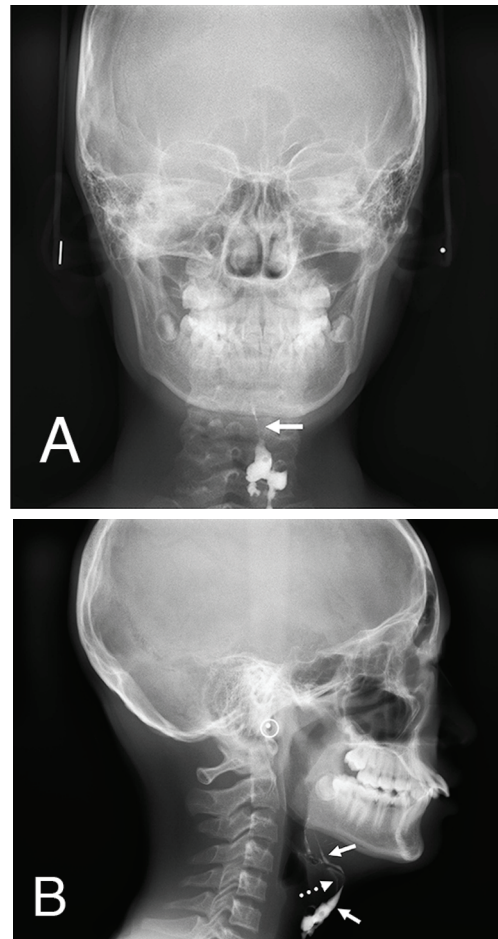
Fistulograms. A. Posterior-anterior radiograph after injection of 76% compound meglumine diatrizoate into the duct through the fistulous opening of the skin in the midline of the neck. The thyroglossal tract can be identified, and the extent and anatomy of the remnant tracts were demonstrated. B. Lateral radiograph showing the location of the cyst, the small fistulous tracts ascending towards the tongue base, and their relationship to the hyoid bone. The white arrows show the tract of thyroglossal fistula, and the dotted white arrow shows the hyoid bone.
